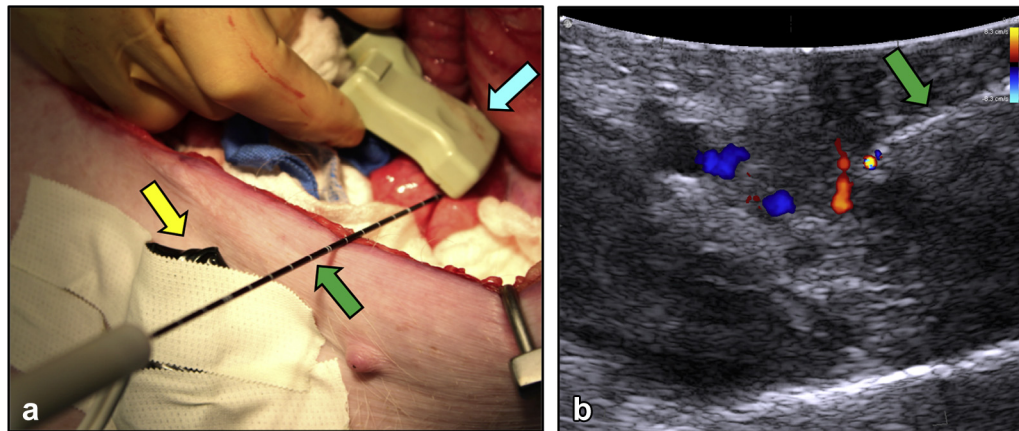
(a) Intraoperative image demonstrating pancreatic placement of SN-HFIRE delivery device (green arrow) under US guidance (blue arrow) and placement of accelerometer (yellow arrow). (b) Representative Doppler US image captured immediately after completion of SN-HFIRE delivery (green arrow shows the SN-HFIRE delivery device).
